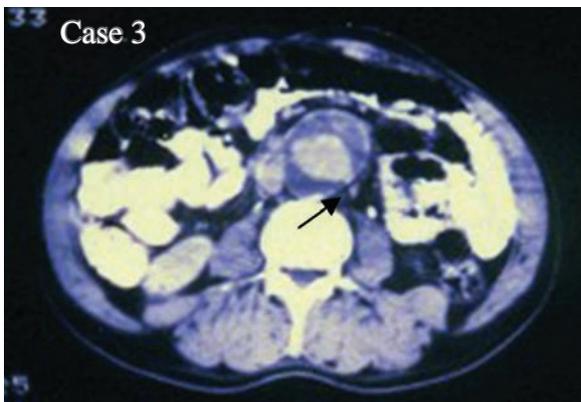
CTA of leaking AAA, 12 cm in diameter.
